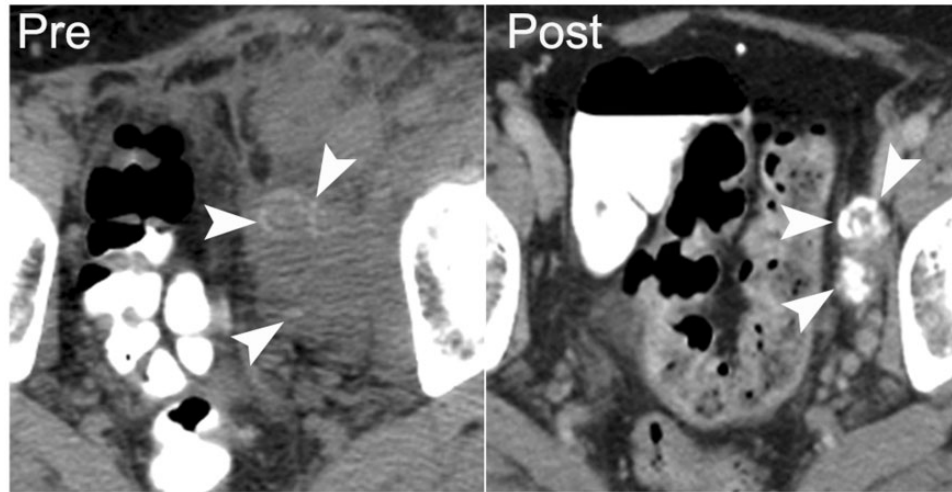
A 45-year-old man with primary retroperitoneal malignant germ cell tumor. Axial noncontrast CT shows the untreated mass with internal calcification (arrowheads on left), which was confirmed as malignant germ cell tumor with extensive necrosis on core biopsy. Five years after neoadjuvant chemotherapy and partial resection, contrast-enhanced CT shows that the treated tumor is densely calcified with minimal visible soft-tissue component (arrowheads on right).
